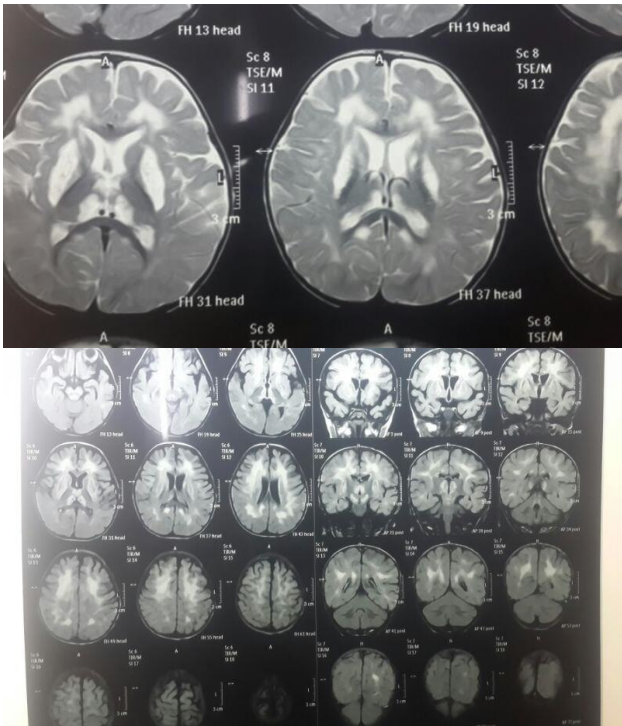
MRI pictures showing hyperdensity in basal ganglia.
